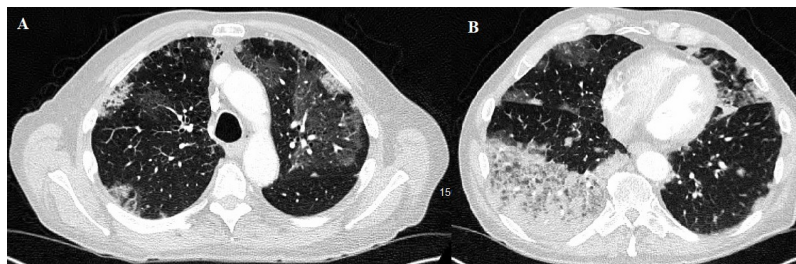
Chest CT scan shows bilateral ground-glass opacities (A) and ill-defined consolidative changes in right lower lobe (B)
